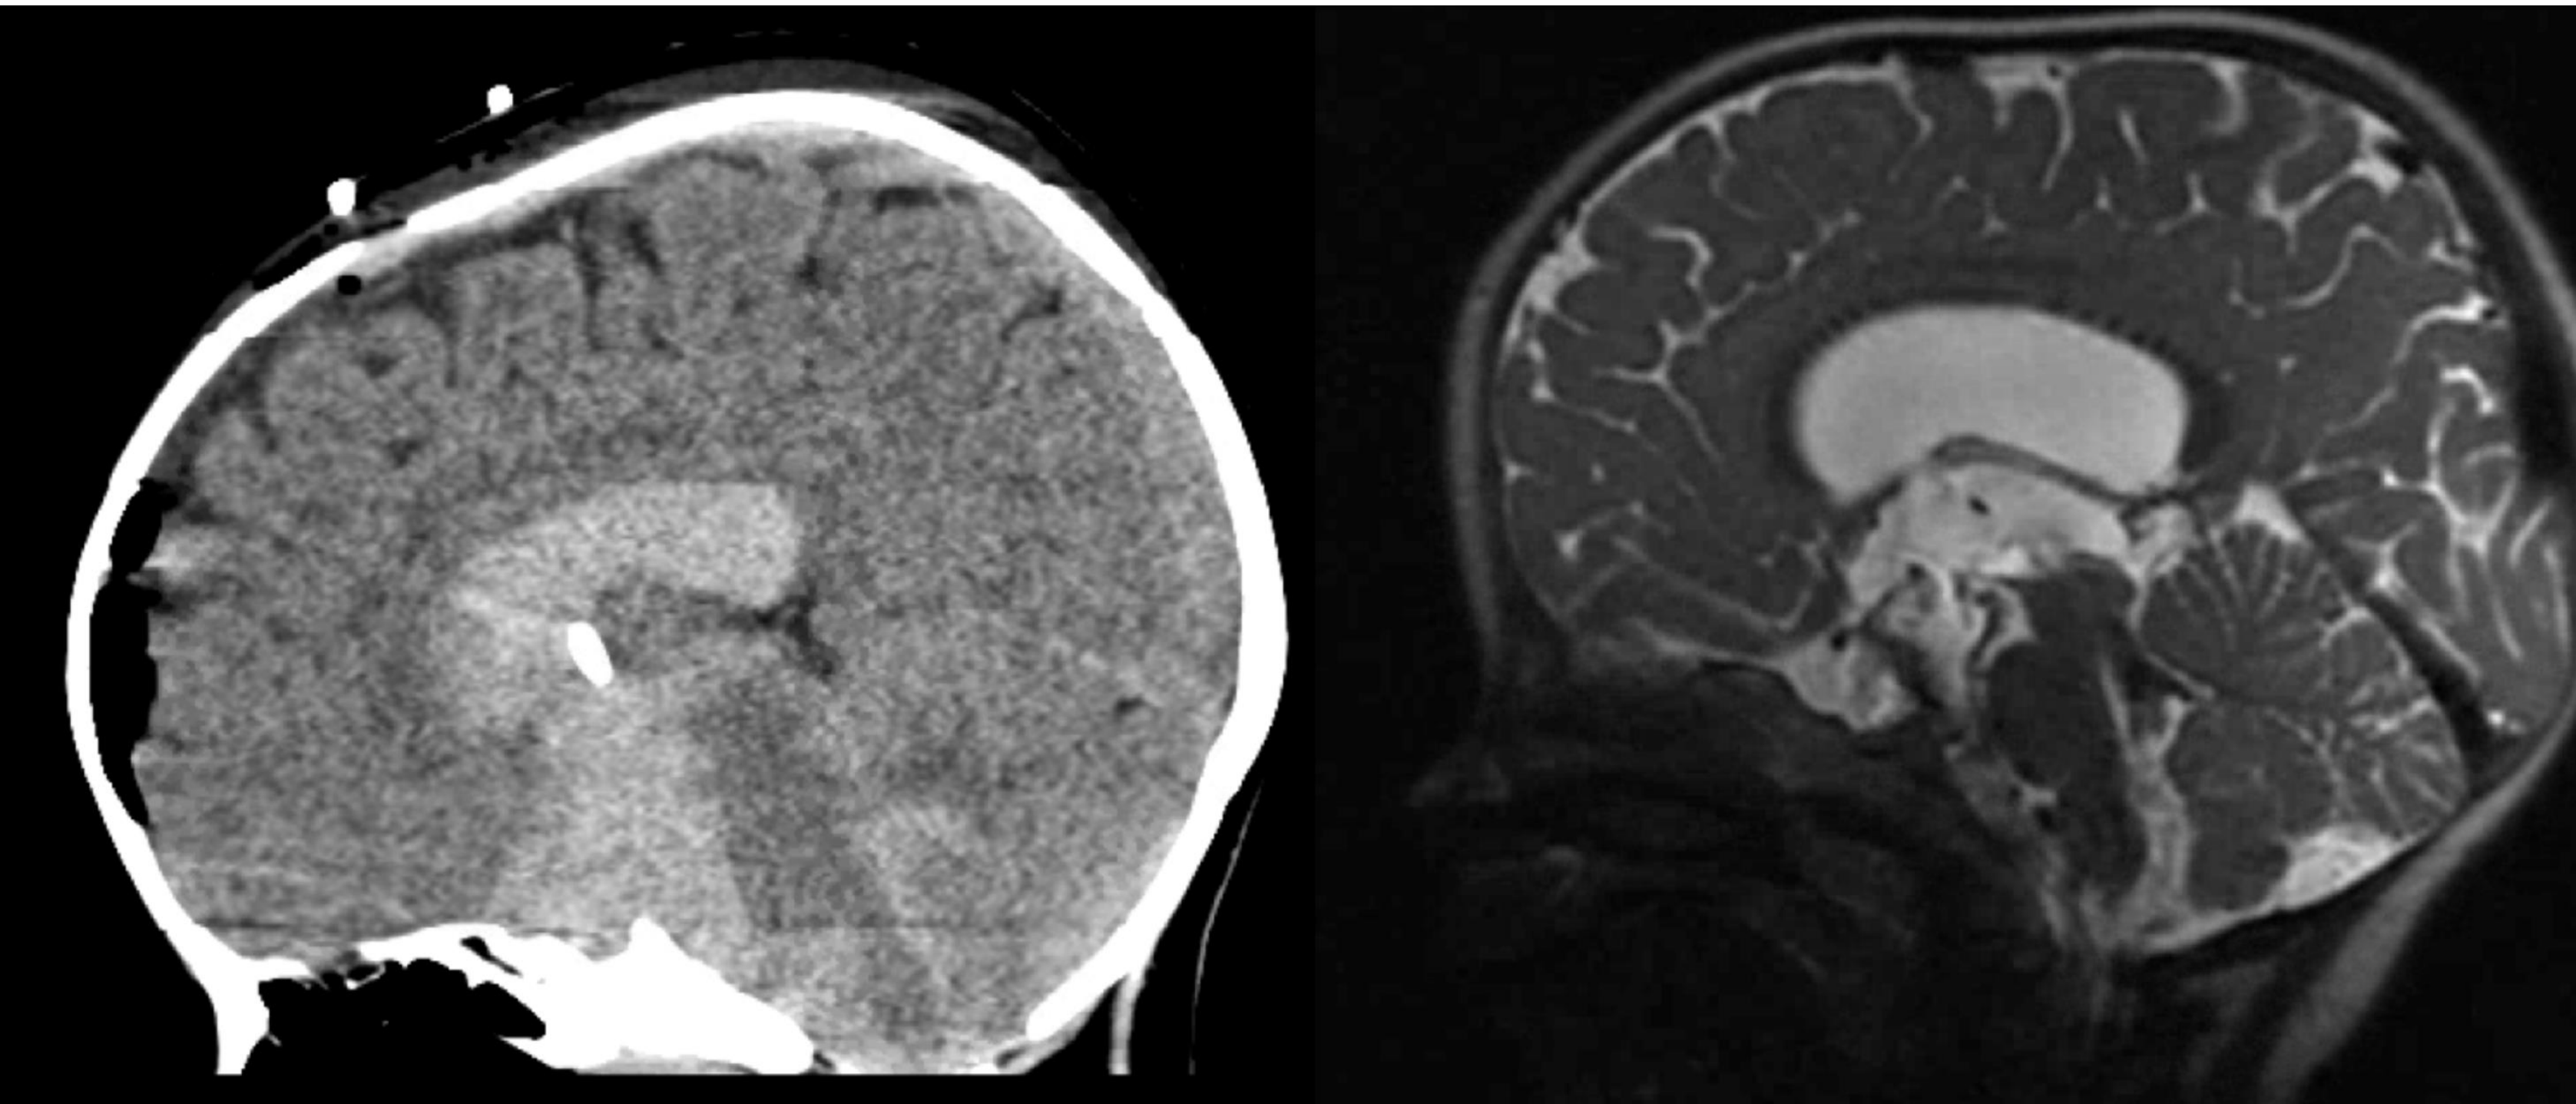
Repeat operation, postoperative CT scans with iodinated contrast demonstrating good flow and lack of cyst recurrence [right scan is 6 weeks post-op]
